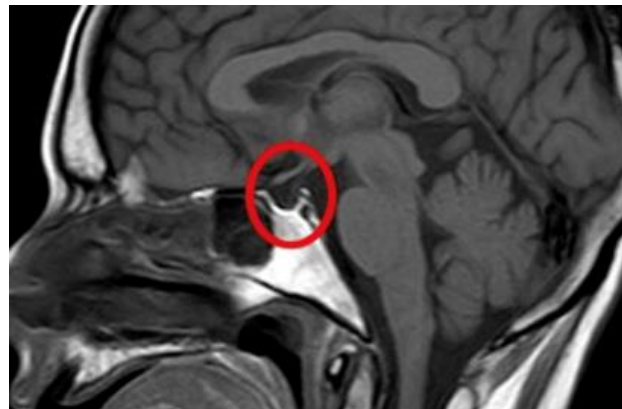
Sagittal T2-weighted MRI showing communication between the intrasellar cavity and the suprasellar cistern (intrasellar arachnoidocele)
